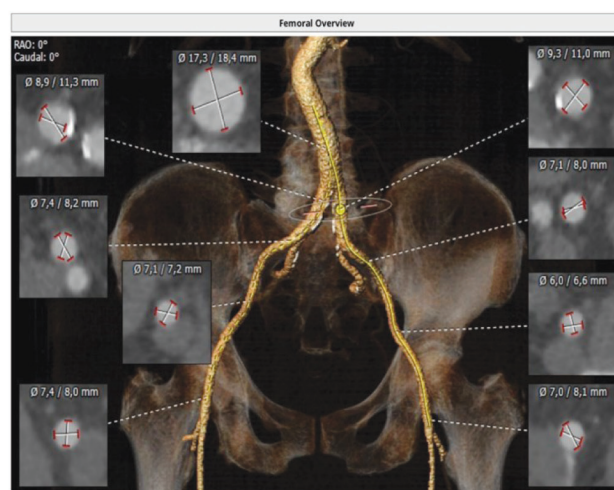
Iliac arteries CT, patient No 3
